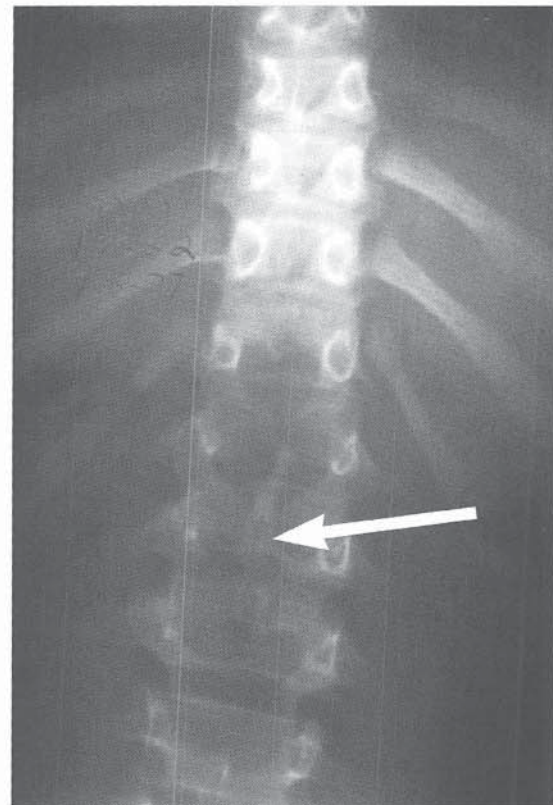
Plain radiographs of a patient with diastematomyelia in the thoracic spine. Note the interpedicular widening around the level of the diastematomyelia. The diastematomyelia spur itself is visible as a spicule of bone in the spinal canal (*arrow*).
